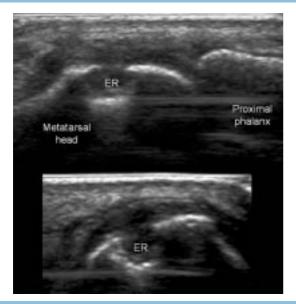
Ultrasonography (grey-scale) demonstrating an erosion of the lateral aspect of the fifth MTP joint in a patient with early rheumatoid arthritis, in longitudinal and transverse planes.
